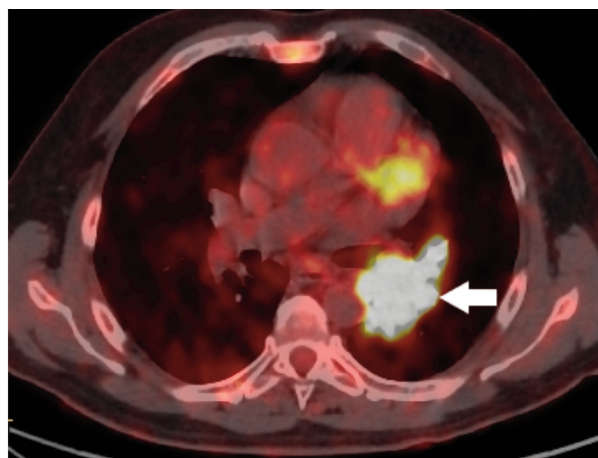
Positron Emission Tomography/Computed Tomography (PET/CT) showing an 18F-Fluorodeoxyglucose avid central lesion, diagnosed as lung inflammatory myofibroblastic tumor.
